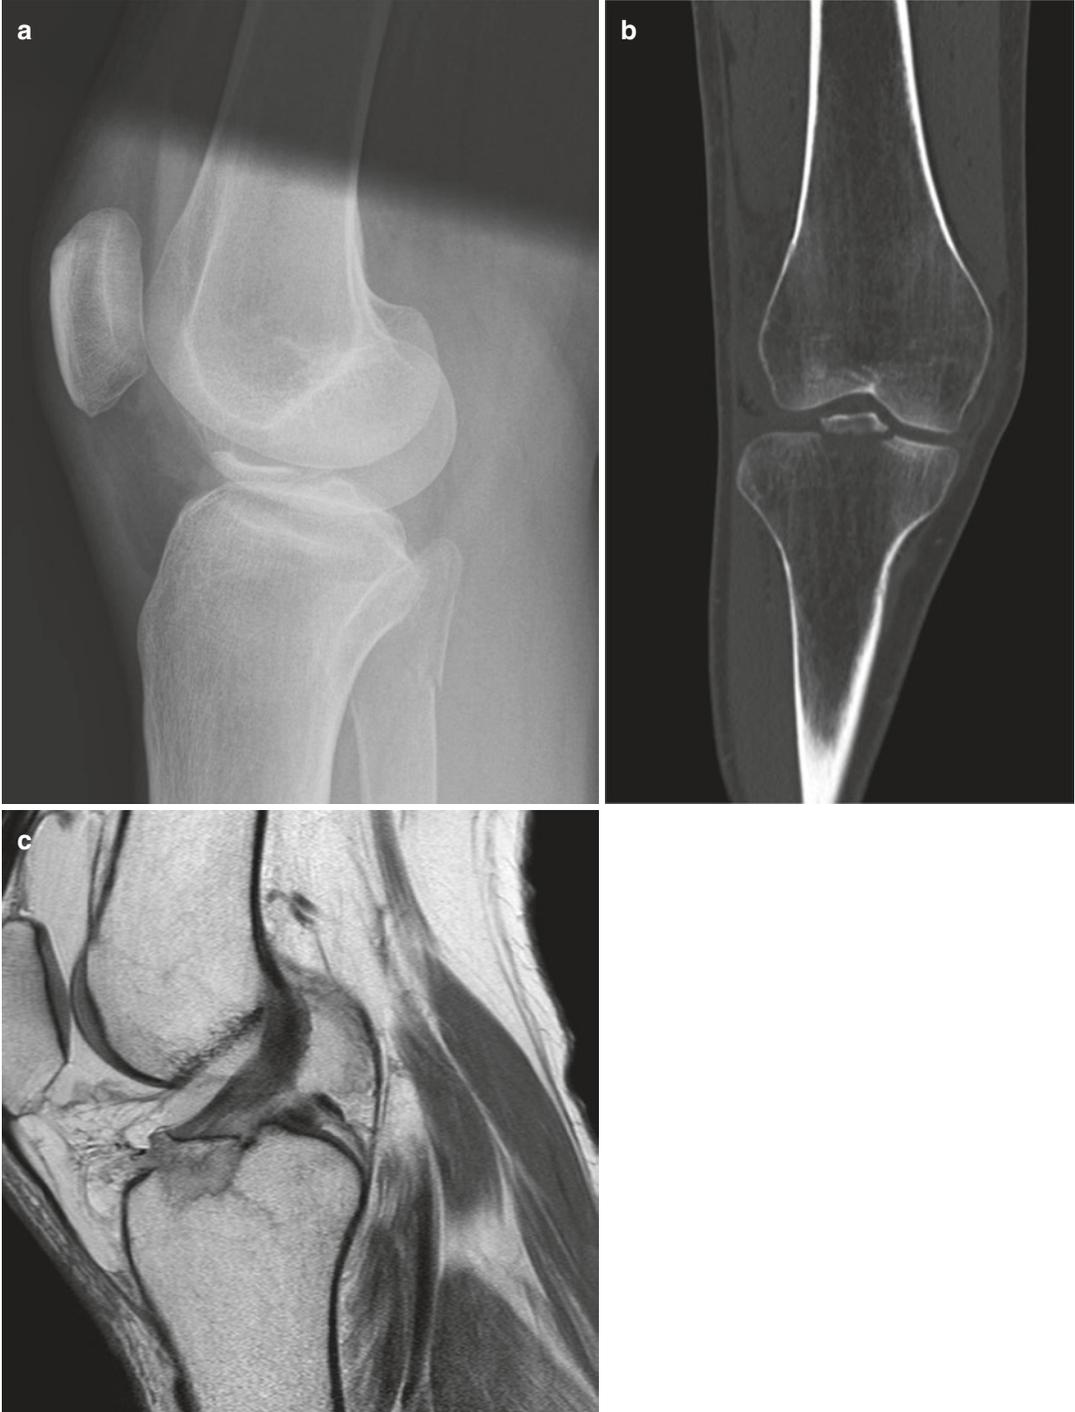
(a–c) ACL tibial spine fracture demonstrated on a lateral plain film (a), coronal CT (b), and T1 MRI sequence (c)
